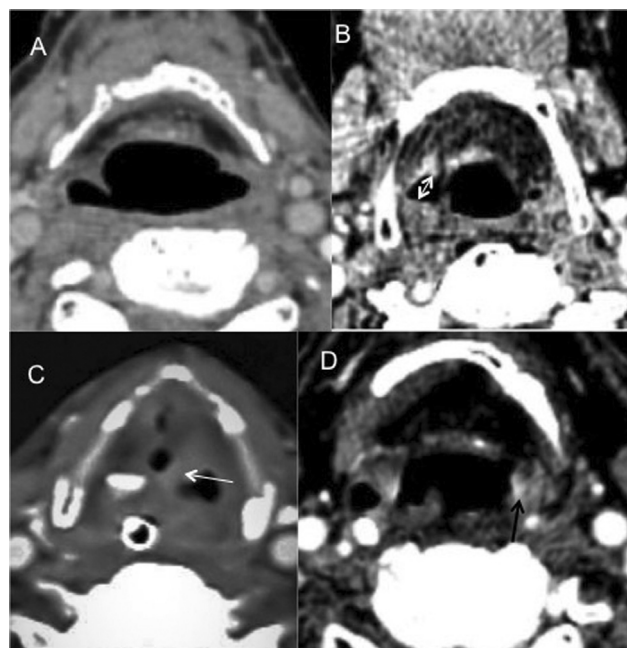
Follow-up computed tomographic scans of postradiotherapy carcinoma of pyriform sinus. (A) Neck Imaging-Reporting and Data System (NI-RADS) 1. (B) NI-RADS 2a—asymmetrical mucosal enhancement on right side (white double arrow). (C) NI-RADS 2b—minimally enhancing soft tissue lesion on left side (white arrow), subsequently positive for recurrent disease. (D) NI-RADS 3—frankly enhancing soft tissue lesion on left side (black arrow).
